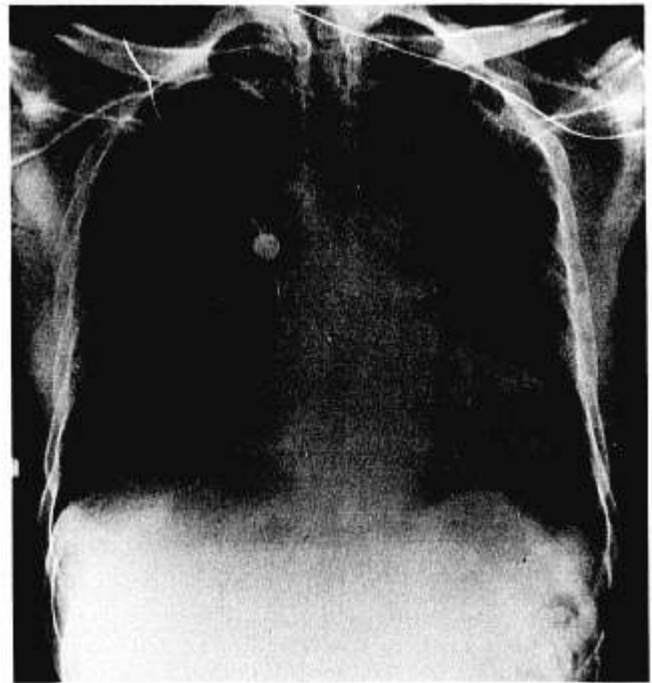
An anteroposterior chest roentgenogram shows the malpositioned catheter in the persistent left superior vena cava. The catheter appears to be located in an upper-lobe division of the left pulmonary artery.
